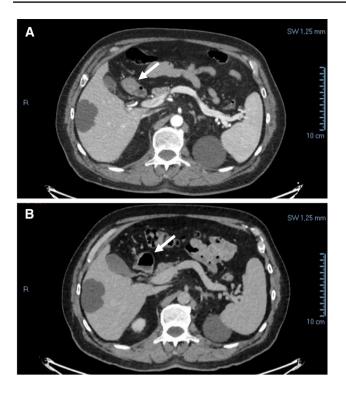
PET-CT scan of the abdomen. A initial image at the diagnosis showing duodenal lesion (white arrow). B imaging shows complete resolution of disease after treatment (white arrow)
